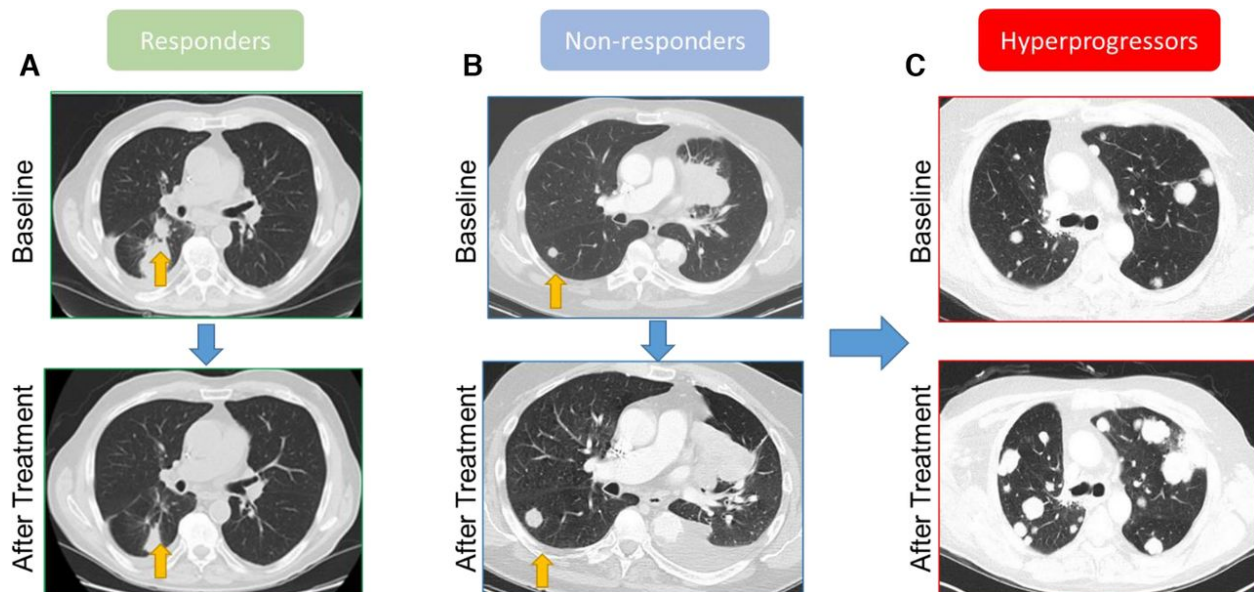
CT scans: (A) responders, (B) non-responders and (C) hyperprogressors. The first row shows baseline CT scans and the second row represents CT scans for the same patient after two cycles of immunotherapy.
